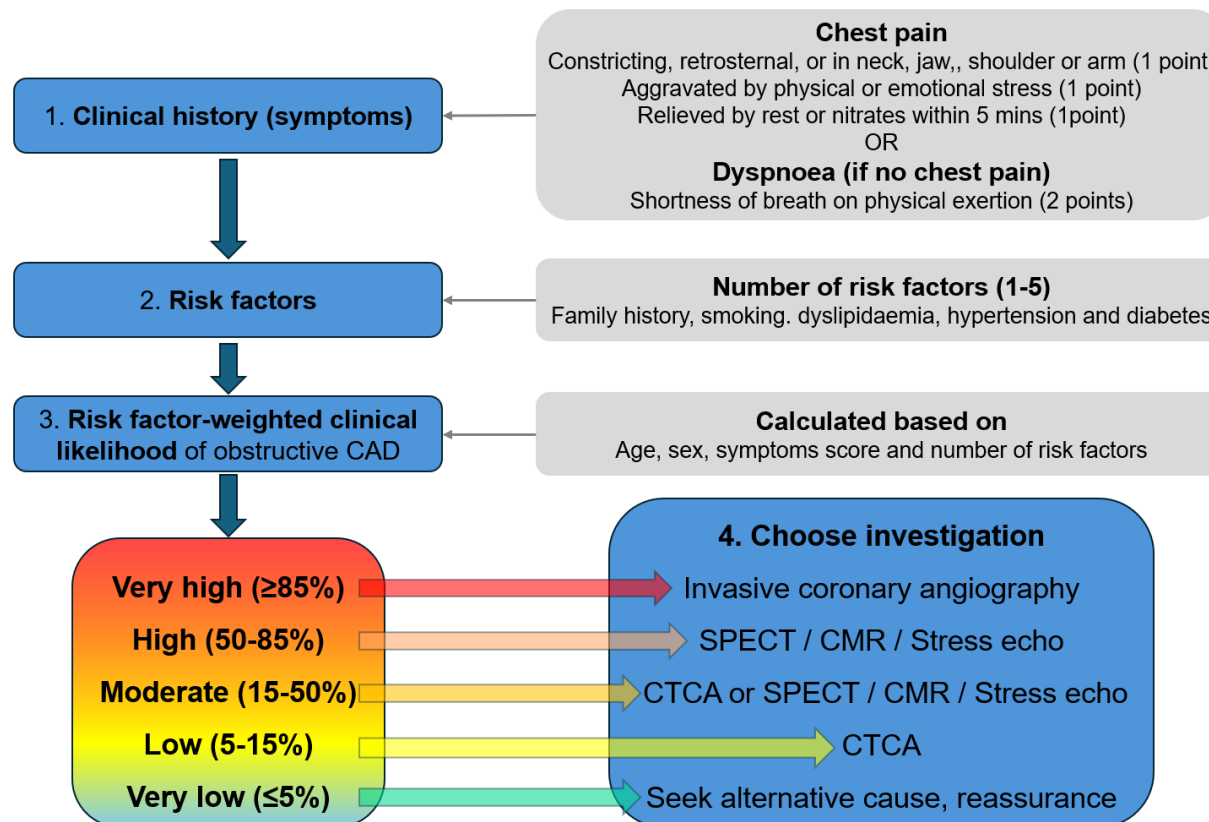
An overview of the clinical assessment and investigation of patients with suspected chronic coronary syndrome. Clinicians must consider the anginal nature of symptoms, burden of risk factors, age and sex of the patient before considering which investigation to best support or exclude a diagnosis. Other factors like local availability, cost and radiation exposure must also be considered, based on the UK National Institute for Health and Care Excellence (NICE, 2010, Vrints et al., 2024) and the European Society of Cardiology guideline documents. (CAD = Coronary Artery Disease, SPECT = Single Photon Emission Computed Tomography, CMR = Coronary Cardiovascular Magnetic Resonance Imaging, CTCA = Computed Tomography Coronary Angiography).
